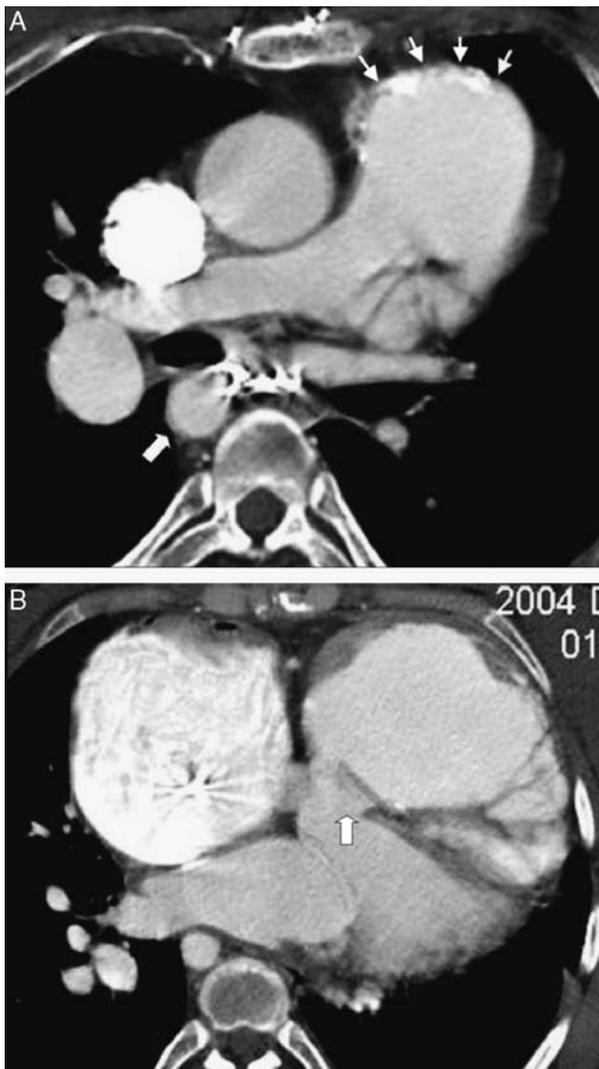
A 22-year-old woman after repair of tetralogy of Fallot who developed a recurrent ventricular septal defect (VSD), pulmonary and tricuspid insufficiency, and right heart failure. A, Contrast-enhanced CT shows deformity and calcification of the right ventricular outflow patch (arrows). There is a right aortic arch with right descending aorta (thick white arrow). There are coils to the left of the descending aorta from prior embolization of MAPCAS. B, Contrast-enhanced CT demonstrated dehiscence of the subaortic VSD patch (arrow) with resultant left to right shunt. The right atrium and right ventricle are dilated. CT indicates computed tomography; MAPCAS, multiple aortopulmonary collateral arteries.
